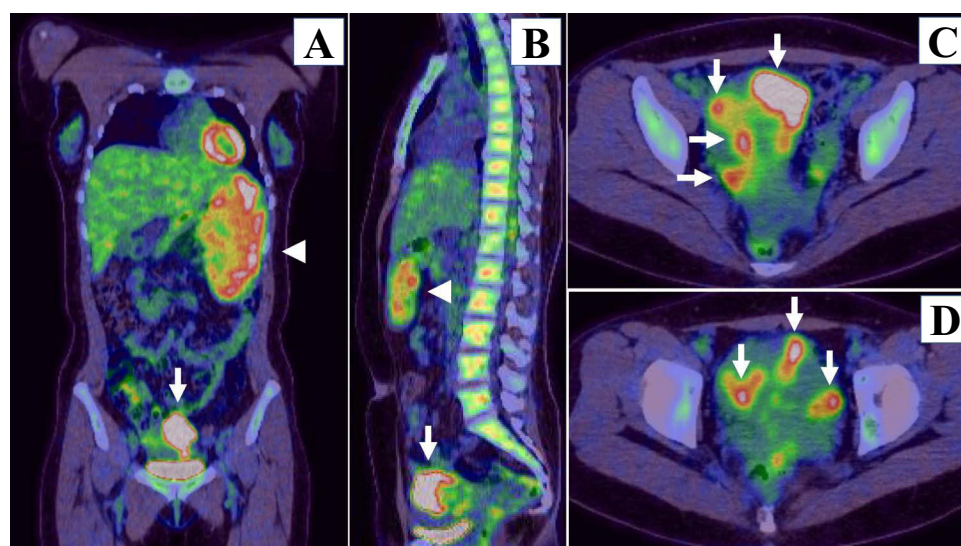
Maximum intensity projection images obtained using fluorodeoxyglucose (PDG) positron emission tomography reveal strong FDG uptake in the enlarged spleen (arrow head) and uterus (arrow) (A) as well as weak uptake in vertebral bodies (B). Mass-like FDG accumulation is seen in the uterine body (C). Nodular accumulations are also seen in the surrounding area (C and D).
